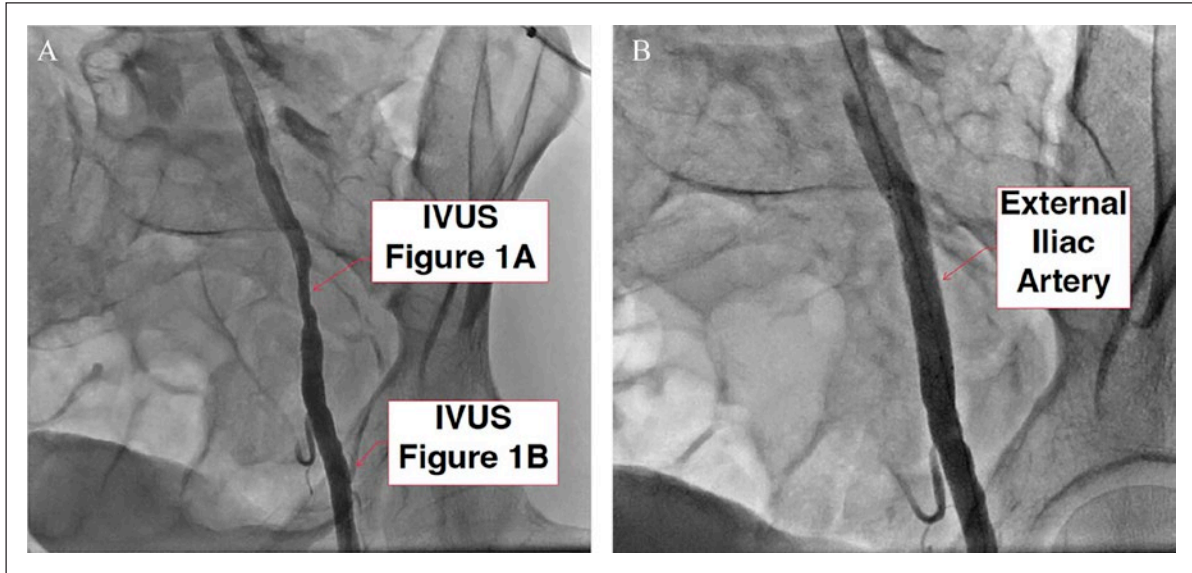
Angiographic images of a 35-year-old woman and avid runner (same patient as in Figure 1) with left external iliac endofibrosis prior to intervention (A) and poststenting (B). The locations of IVUS images from Figure 1 are shown in (A). Note: the stenosis was found to be a fixed lesion. There was no spasm or wire bias. Evaluation for fibromuscular dysplasia was negative. IVUS, intravascular ultrasound.
